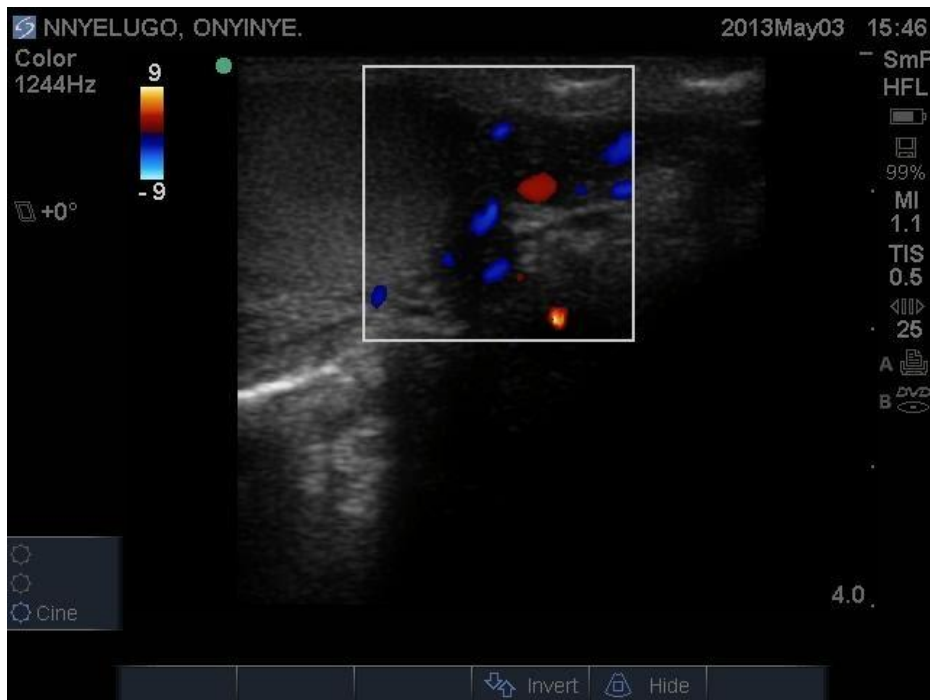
Doppler ultrasound of the testis
